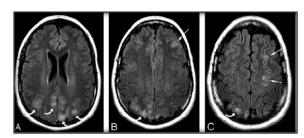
MR imaging of PRESS:Demonstrates patchy vasogenic edema in the parietal region (curved arrows) bilaterally along with linear involvement alongthe superior frontal sulcus on the left.
